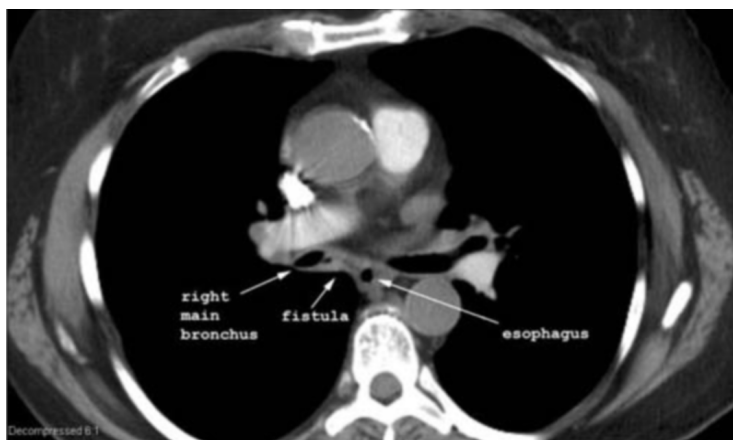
59-year-old woman with congenital bronchoesophageal fistula. Noncontrast axial CT (mediastinal windows) through subcarinal region shows small air collection between the right mainstem bronchus and the esophagus.
